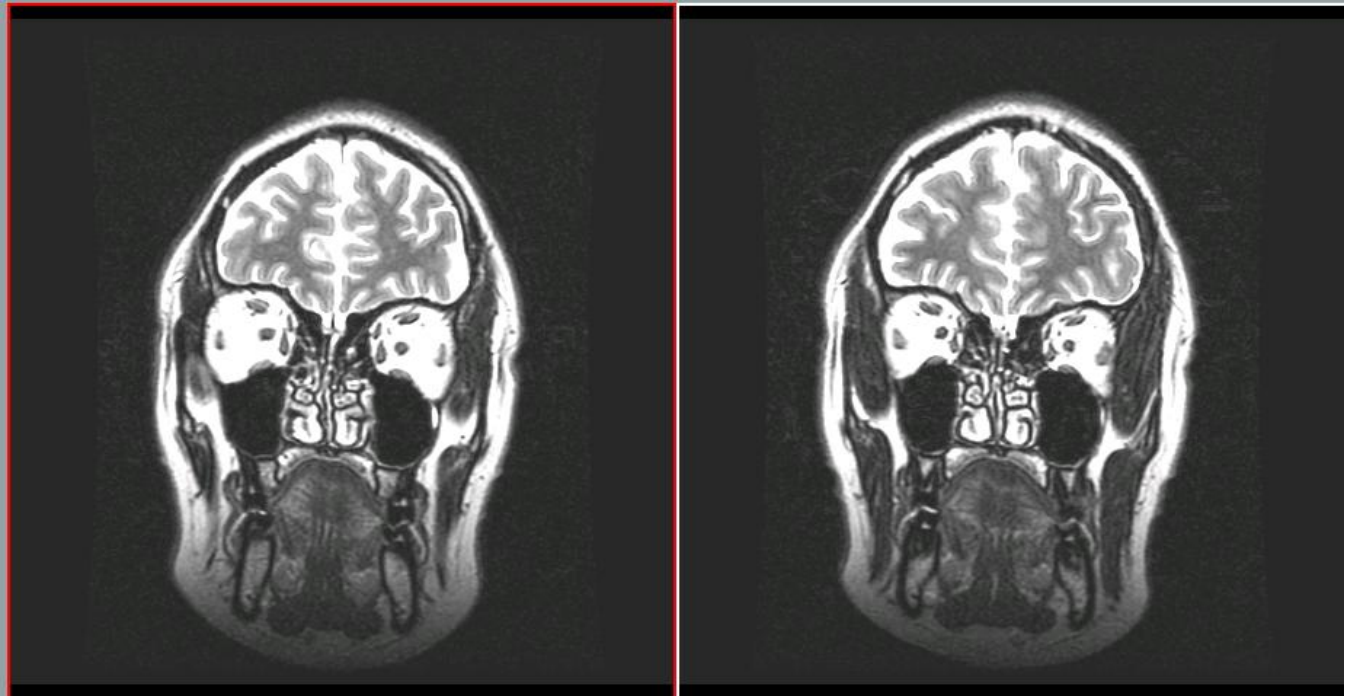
MRI Brain of the patient with CSF rhinorrhoea visualizing the defect and site of leak.
